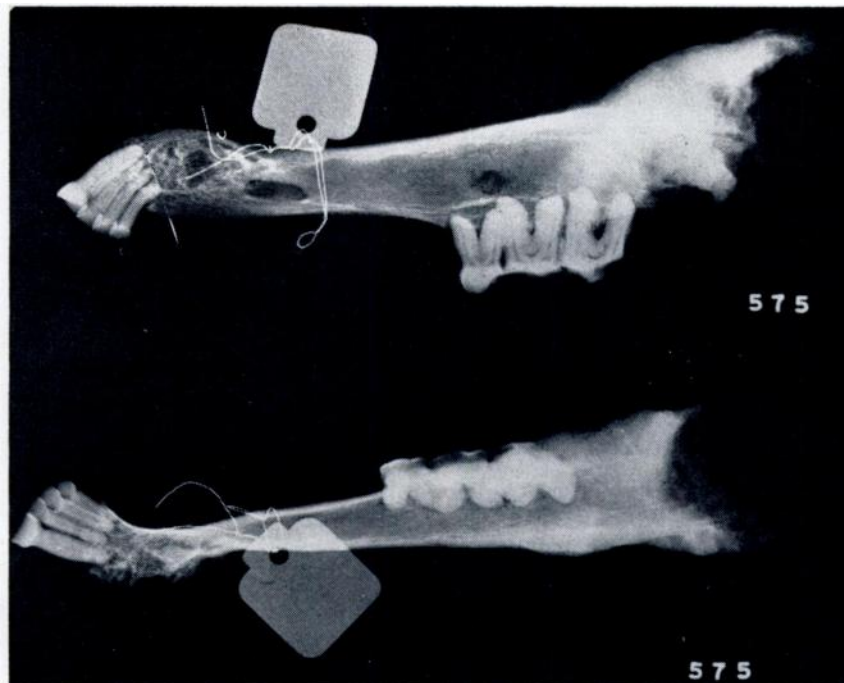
Radiograph of bone growth on fragmented elk mandible shown in Fig. 3. It shows the internal honeycombed appearance of the bone and its cavitation at the level of the fracture, which are characteristic of actinomycosis.
